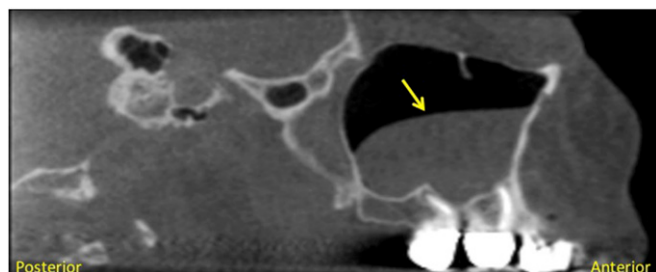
CBCT slice in the sagittal plane of the left maxillary sinus showing the mucous retention pseudocyst (arrow).
